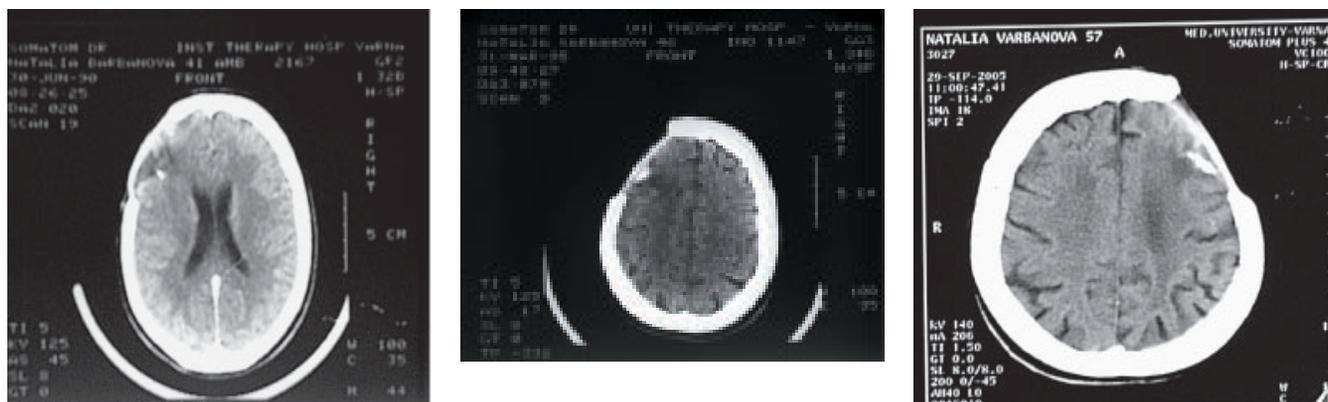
CT scans show no recurrent tumor mass.
